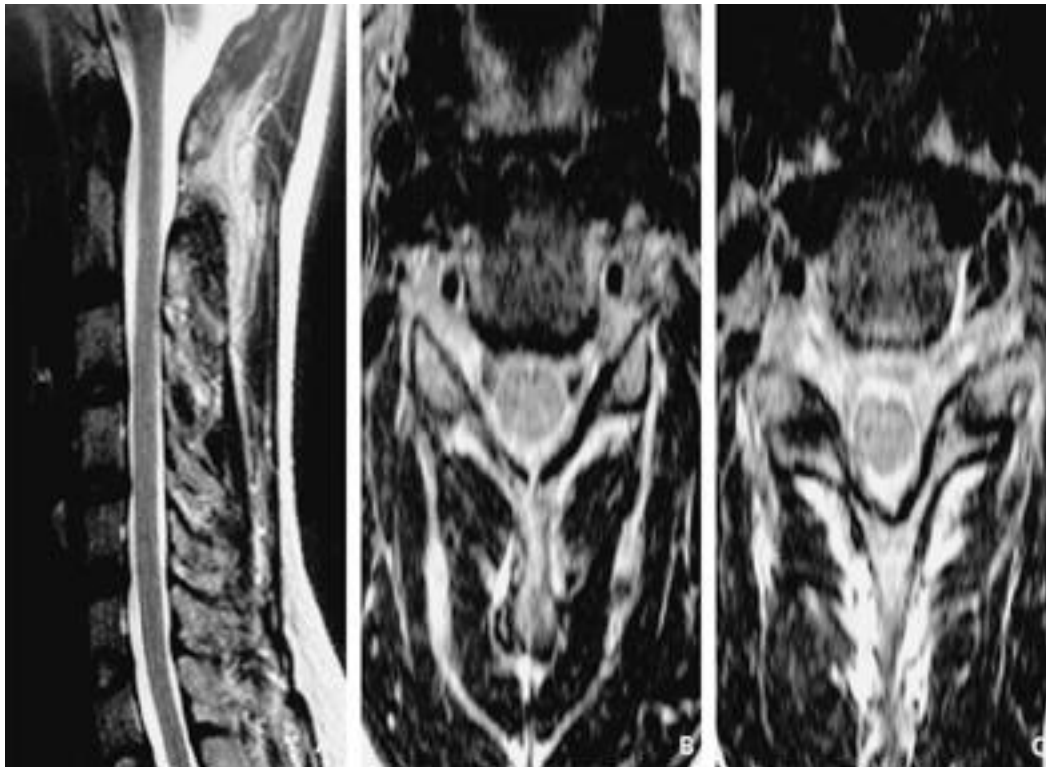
The MRI of the cervical spine shows normal findings without herniated disc and spinal cord compression. A. T2 weighted sagittal MRI. B. T2 weighted axial MRI at C4-5. C. T2 weighted axial MRI at C5-6.
